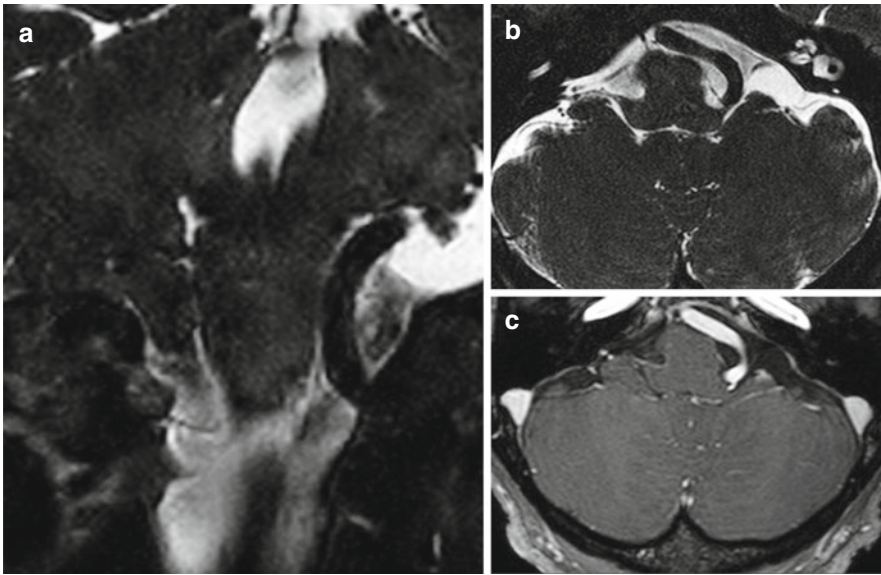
MRI in a patient harboring left vagoglossopharyngeal neuralgia together with apparent essential arterial hypertension. (a) Coronal view of T2 high-resolution sequence showing compression of the ventrolateral aspect of medulla by vertebral artery (VA) on left side (*arrow*).
